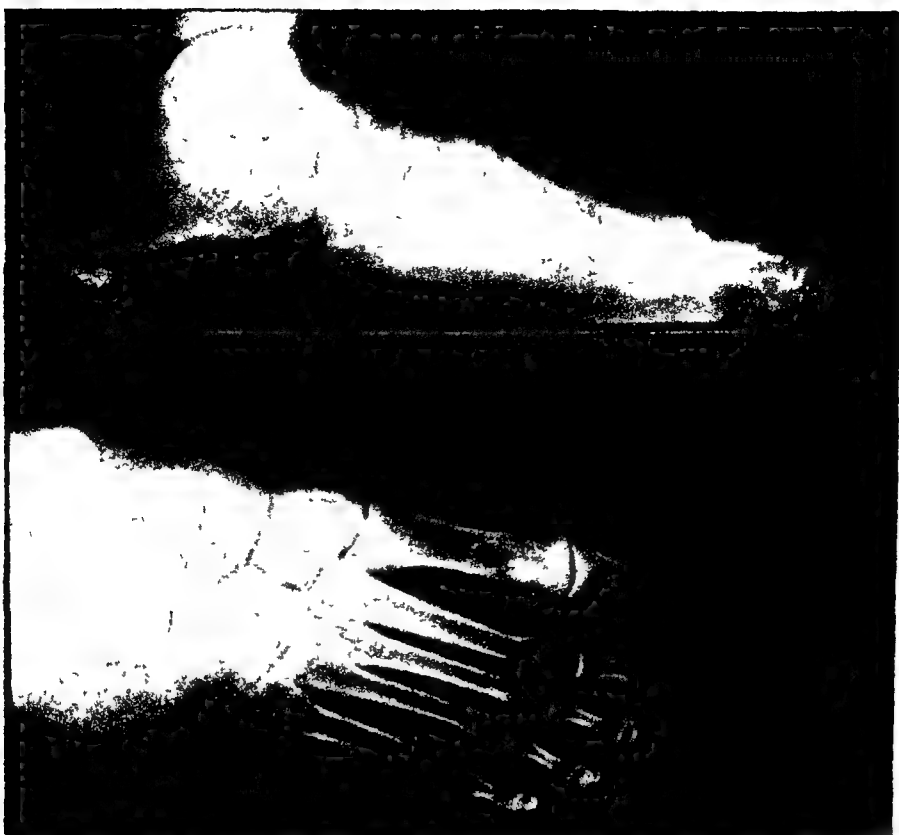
RADIOGRAPH OF PATHO-ANATOMICAL CASE REPORTED.
